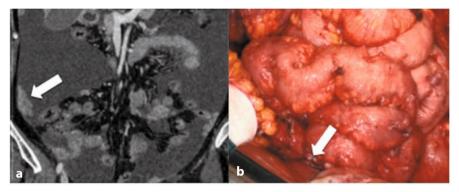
Coronal contrast-enhanced computed tomography (CT) image showing (a) multiple nodules with a diameter > 5 mm diffusely involving the tunica serosa over bowel loops and paracolic gutters (*arrows*), (b) as documented during surgical intervention (*arrow*)
